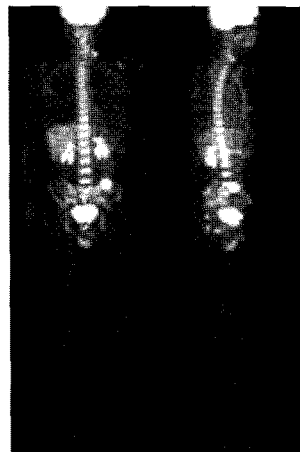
Maximum intensity projection image of FDG PET/CT showed multiple nodular uptakes with varying degrees of FDG uptake (arrow) throughout whole body.
